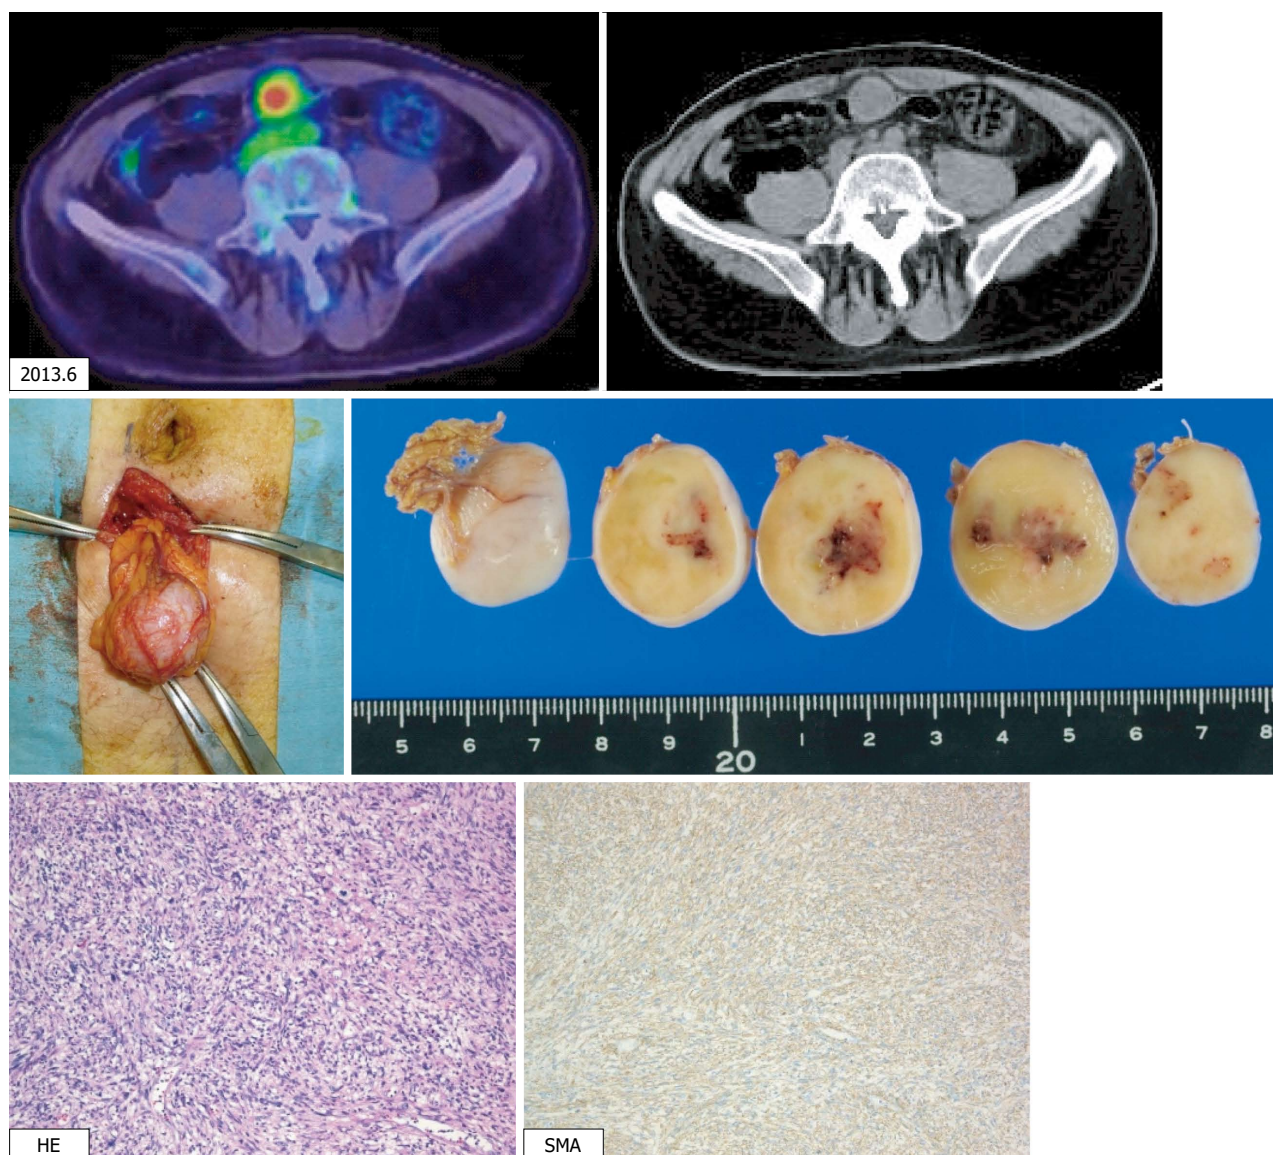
Peritoneal recurrences. A tumor just below the peritoneum was discovered. As the accumulation was recognized in a positron emission tomography-computed tomography scan and no other accumulation was observed, extirpation of the tumor was carried out. Pathological diagnosis was leiomyosarcoma of the omentum, compatible with recurrence. SMA: Smooth muscle actin.
